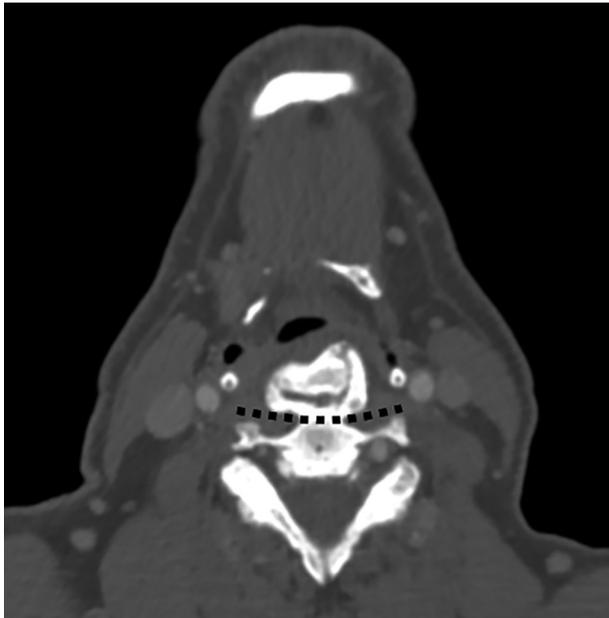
Cervical CT scan : prominent osteophyte delimited by the dotted line inducing an esophageal compression.
